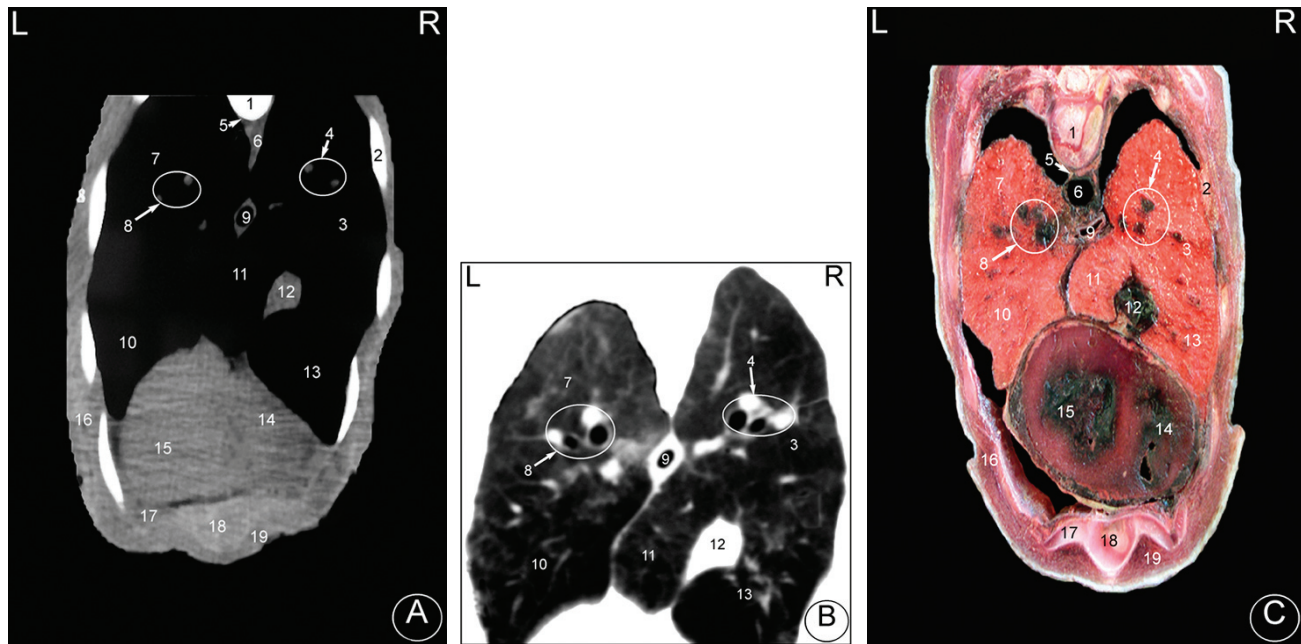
Transverse images at the level of the pulmonary trunk bifurcation into the right and left pulmonary arteries. (A) CT-soft tissue window image, (B) CT-lung window image and (C) Anatomical cross-section. L: Left; R: Right.
